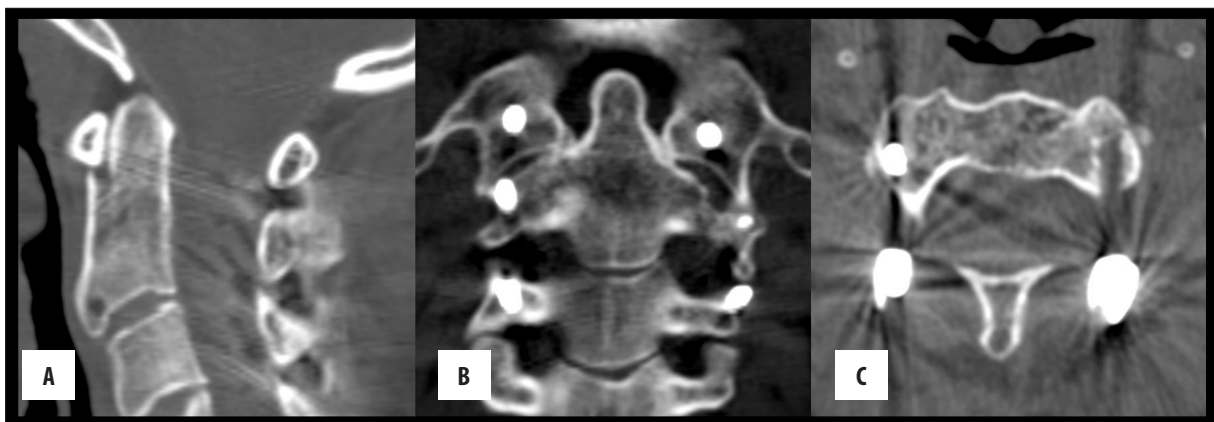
Sagittal (A), coronal (B) and axial (C) CT-images 18 months after bullet removal and dorsal stabilization of the cervical spine with spondylodesis. The bone structure of the C2 vertebral body healed completely.
